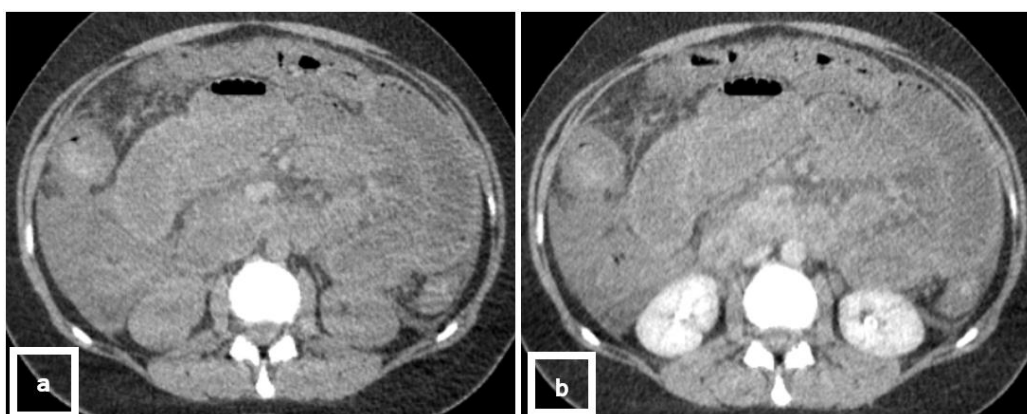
CT scan in axial view, (a): Without Contrast and (b): With Contrast in Portal phase: Revealed a diffuse mural thickening (up to 12 mm) observed in the ileo-jejunal loops, right colon, displaying a target sign with submucosal edema. Several ileo-jejunal loops appeared hyperdense and lacked post-contrast enhancement, Additional findings included extensive mesenteric fat stranding, a significant peritoneal effusion, and a collapsed inferior vena cava suggestive of ischemia
